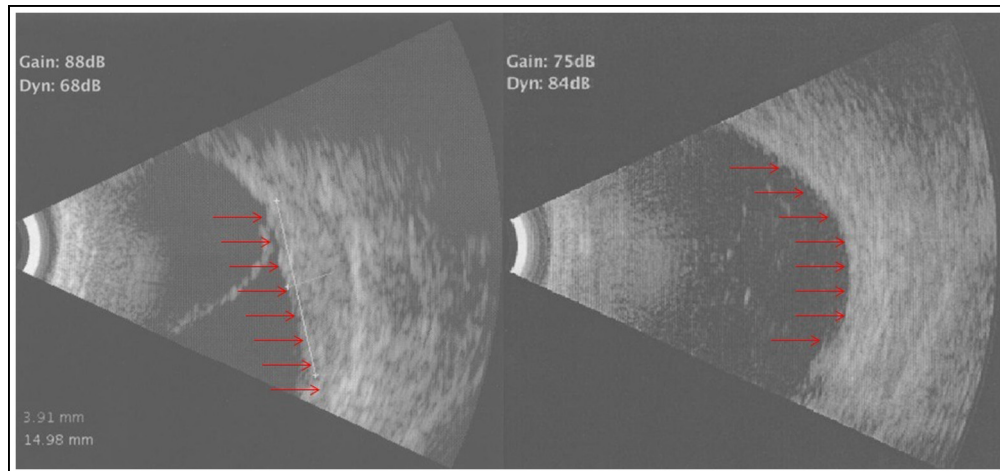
Ultrasound examination of left eye. (A) At initial presentation, a 3.6 mm solid mass with intermediate to high reflectivity was noted (red arrows), without any extraocular extension. (B) After completion of radiation and chemotherapy, complete flattening of lesion was noted (red arrows).
